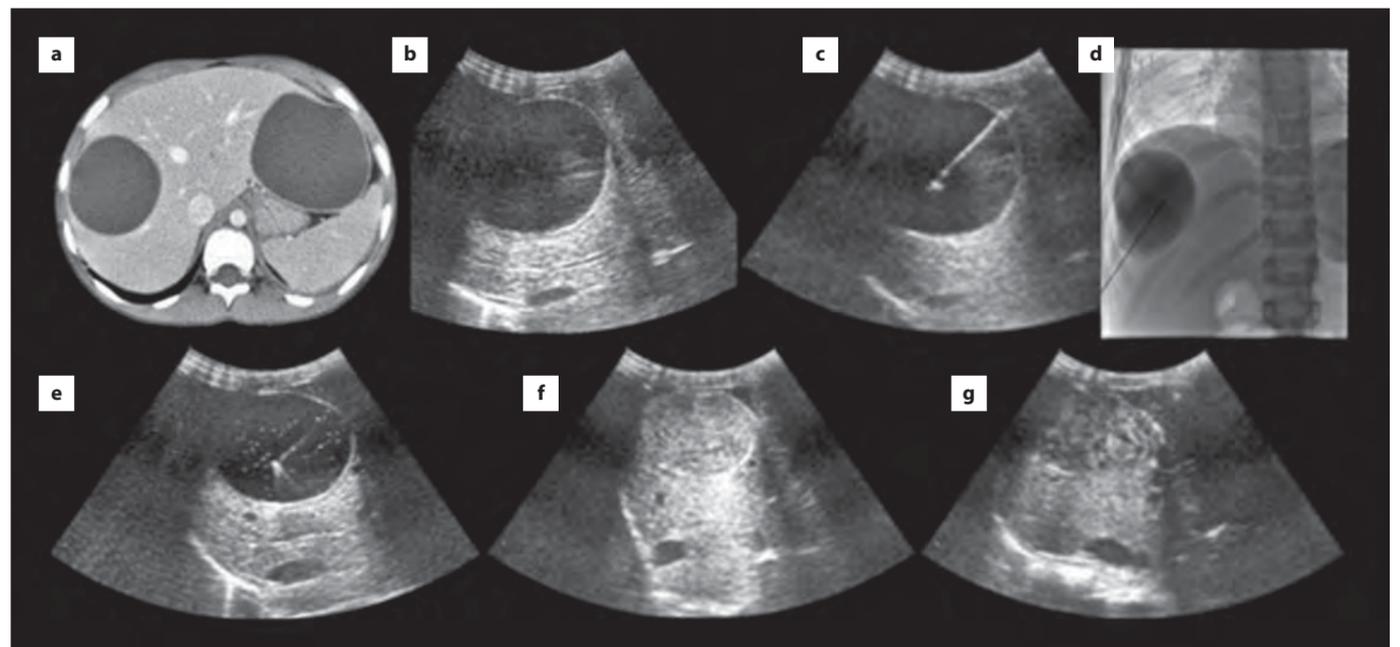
CE 1 (according to WHO classification) with double-contour sign were detected on an abdominal CT and US examination of 10-year-old female patient. (a-b) Percutaneous treatment was performed using PAIR (c-f). 2-year follow-up ultrasound showed a "pseudo-tumour appearance" representing a dead remnant (g).
